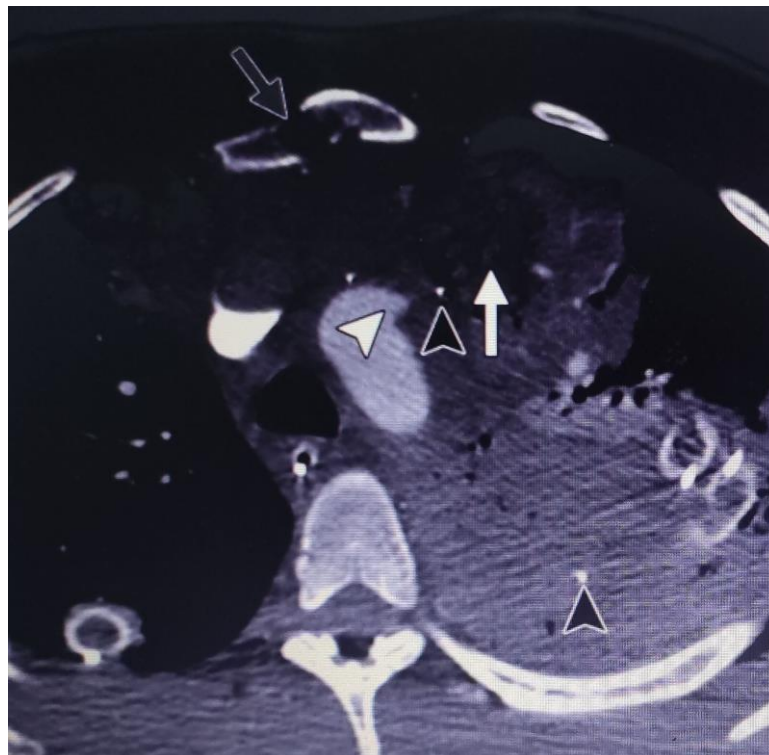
Penetrating wound. Hemopneumothorax. A - penetrating gunshot wound. Tension (translocation of mediastinal organs to the uninjured side) hemopneumothorax. Native CT - high-intensity blood clot in the right pleural cavity (green arrow). Collapsed lung (red arrow). Metal fragment of the balloon in front of the descending aorta (blue arrow). B - penetrating gunshot wound. Tension hemopneumothorax on the left. Acute hemorrhage. Contrast-enhanced CT: rupture of the left lung and leakage of contrast medium from the lobar pleural cavity (red arrows).
